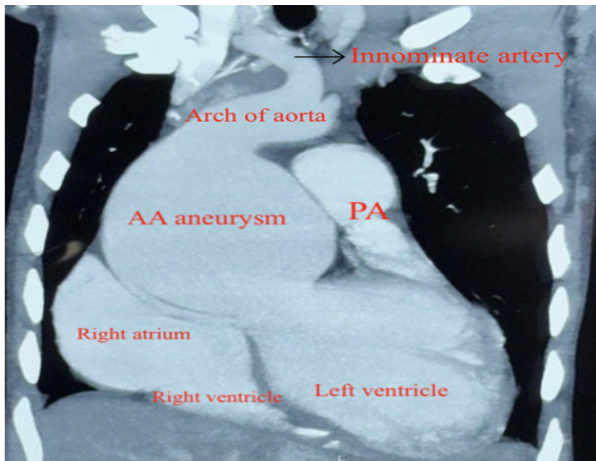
CT aortogram showing enlarged CT ratio and ascending aorta aneurysm.
